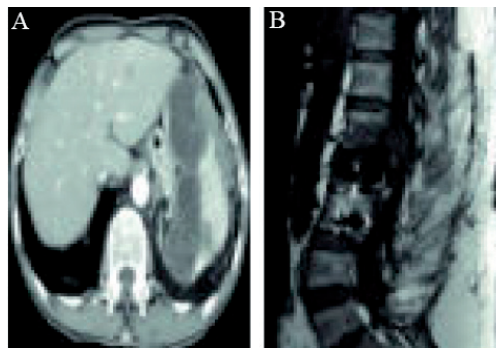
(A) Axial T2 weighted MRI showing splenic hydatid cyst and (B) coronal T2 weighted scan of hydatid disease in L4-5 vertebra.
